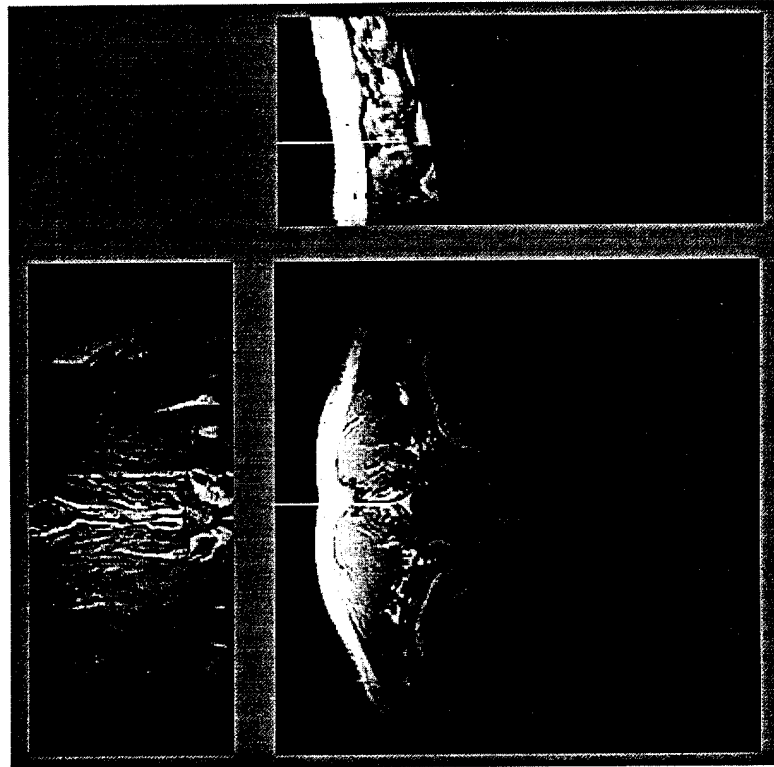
Figure C-21: *MRI Data showing the needle and the surrounding tissue.*
